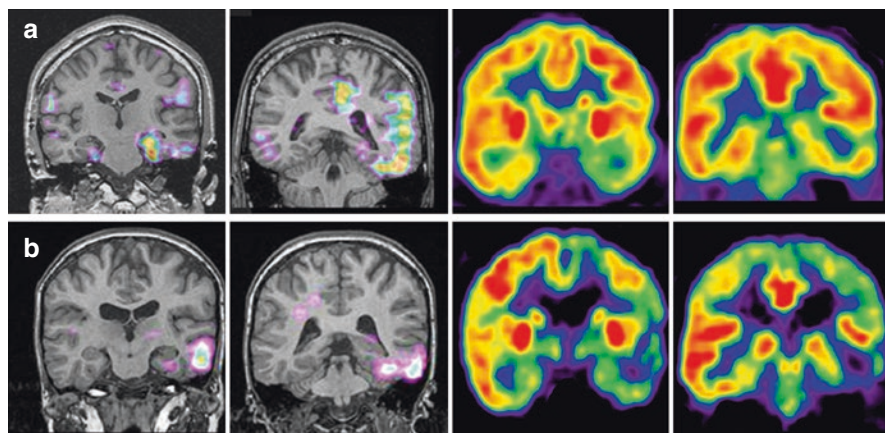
SISCOM and FDG-PET findings in a MLTLE and a LTLE patient. (a) Left upper two SISCOM images show ictal hyperperfusion in left mesial and lateral temporal regions during seizure, and right upper two FDG-PET images depict interictal hypometabolism in the left mesial and lateral temporal regions in a MLTLE patient. (b) Lower row shows ictal hyperperfusion in left middle–inferior temporal gyrus and posterior basal temporal regions (left two SISCOM images) and interictal hypometabolism in the left hemisphere, especially in the lateral and basal temporal and frontoparietal regions (right two FDG-PET images) in a LTLE patient
